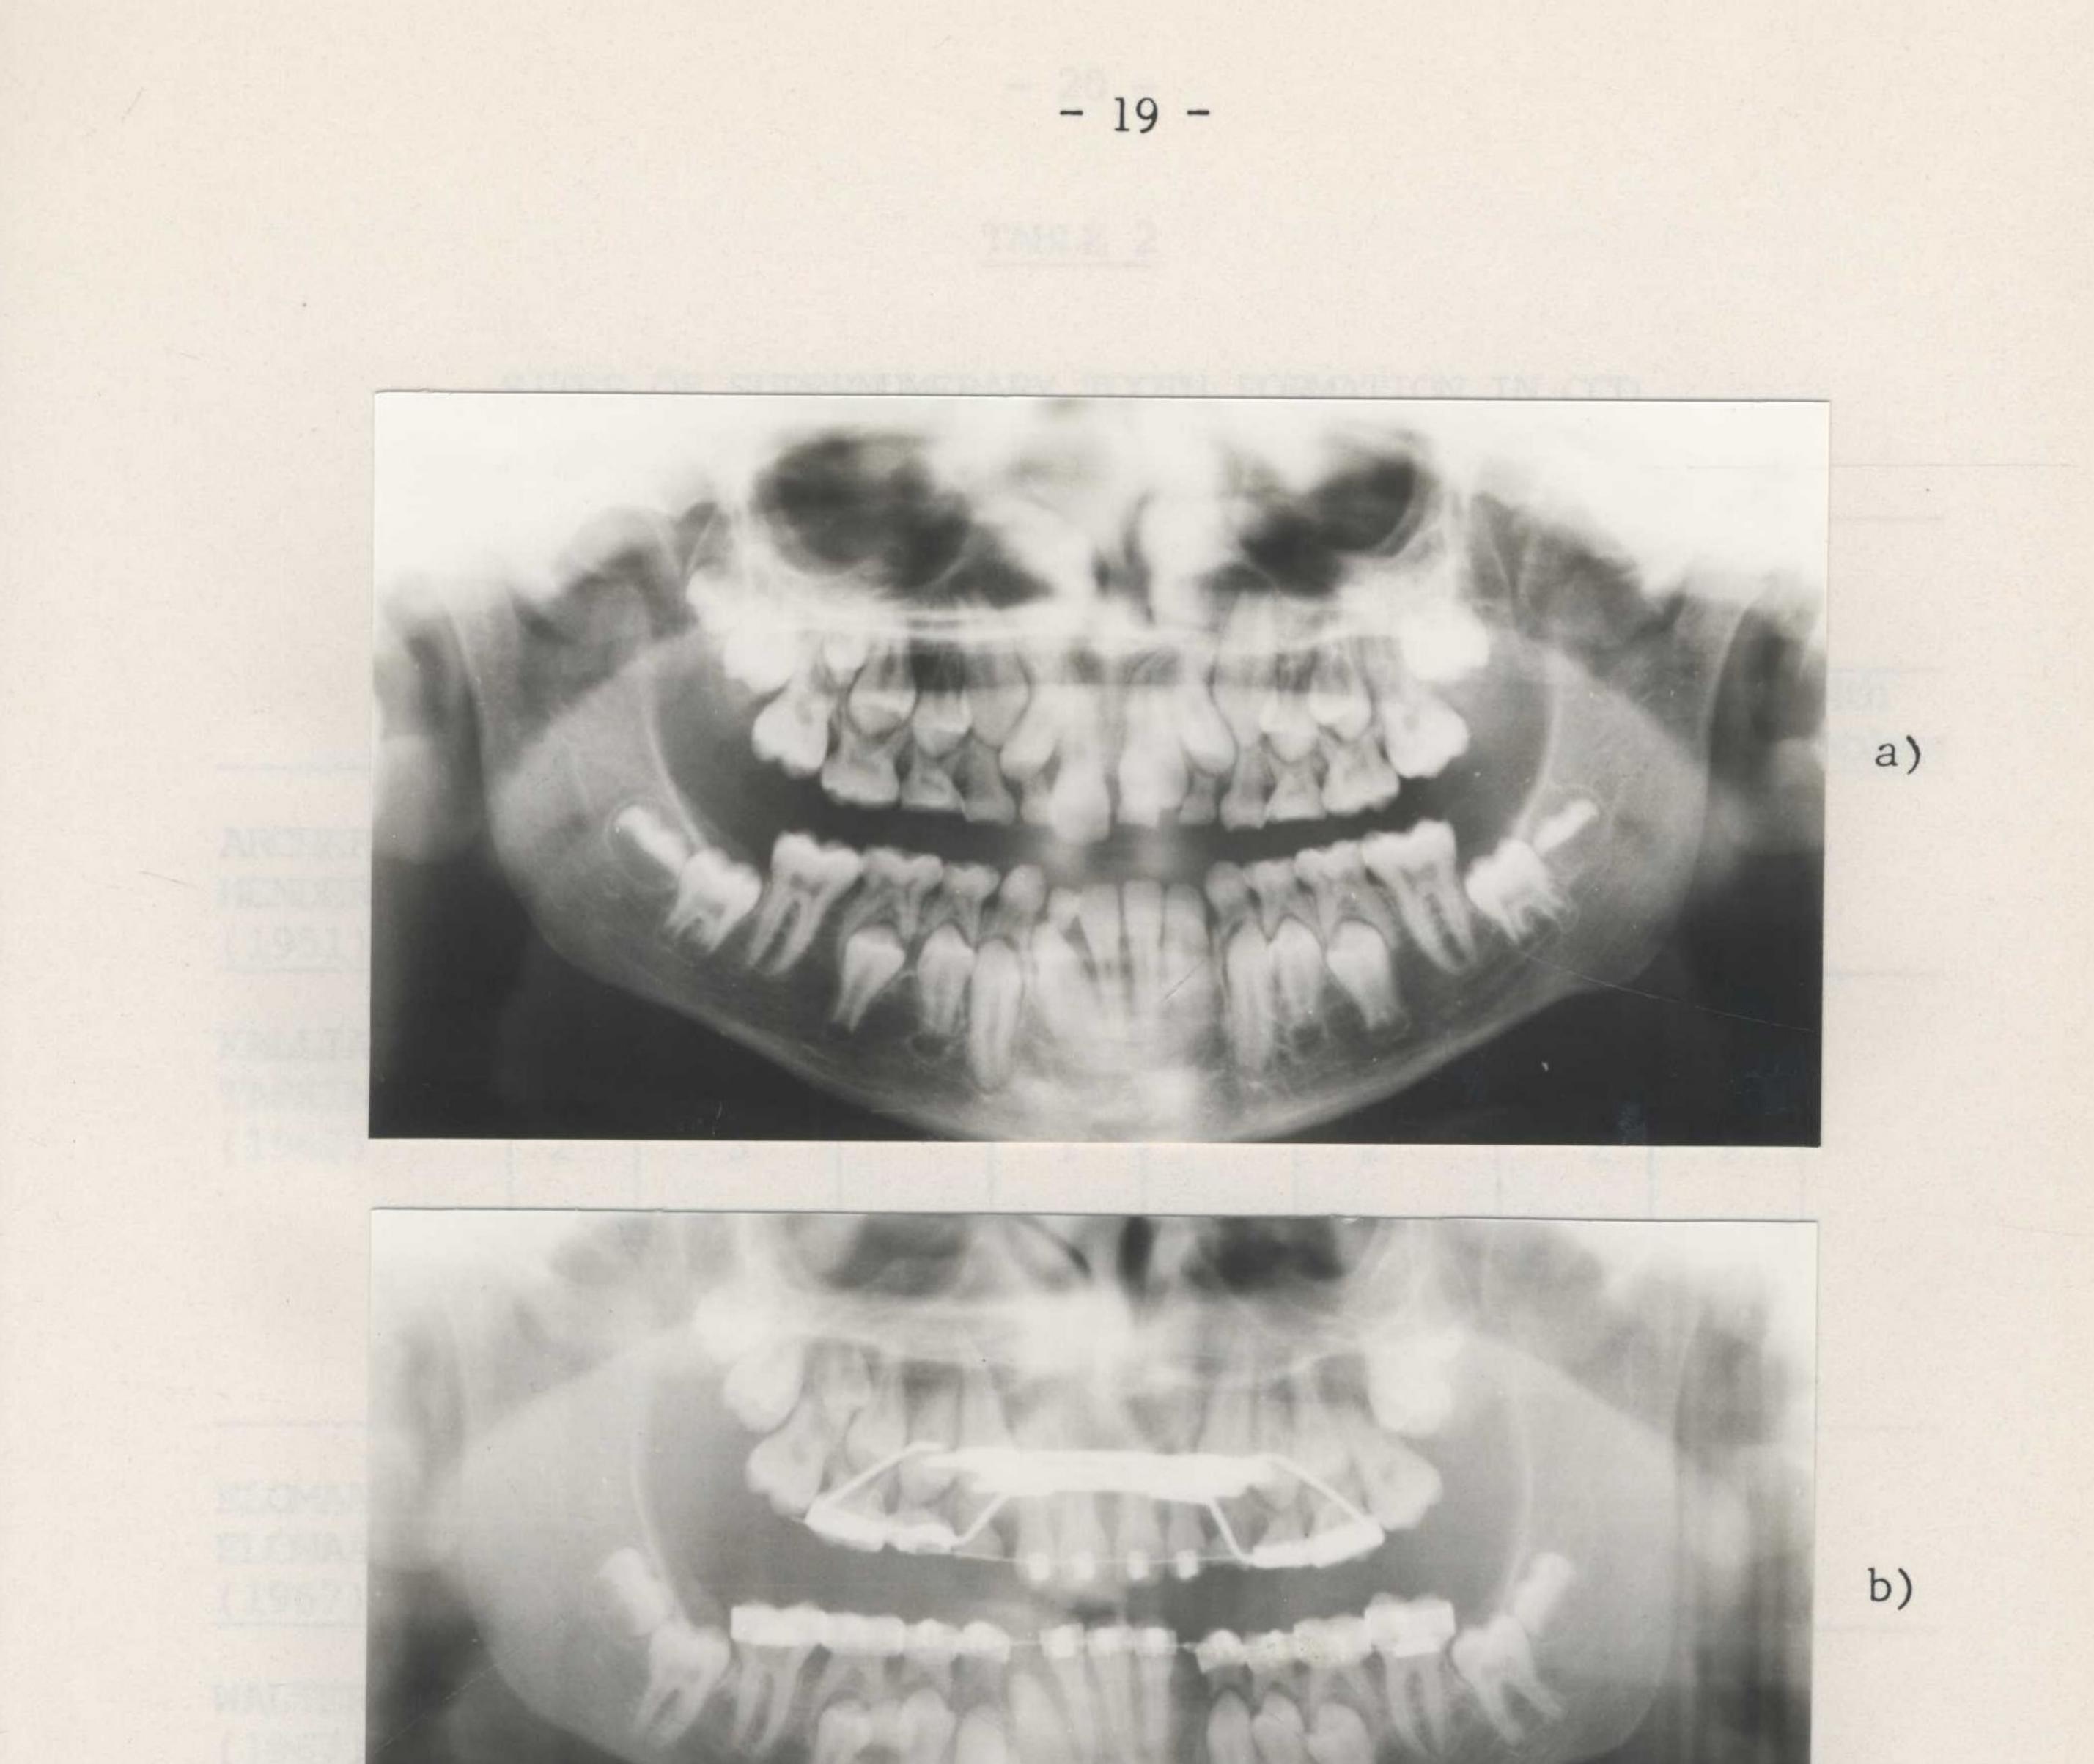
a) Panoramic radiograph of a twelve year old boy with cleidocranial dysplasia. Note the supernumerary tooth distal to the upper right second premolar. b) Panoramic radiograph of the same boy at fifteen. Note the development of an additional supernumerary tooth between the lower right first and second premolars.
